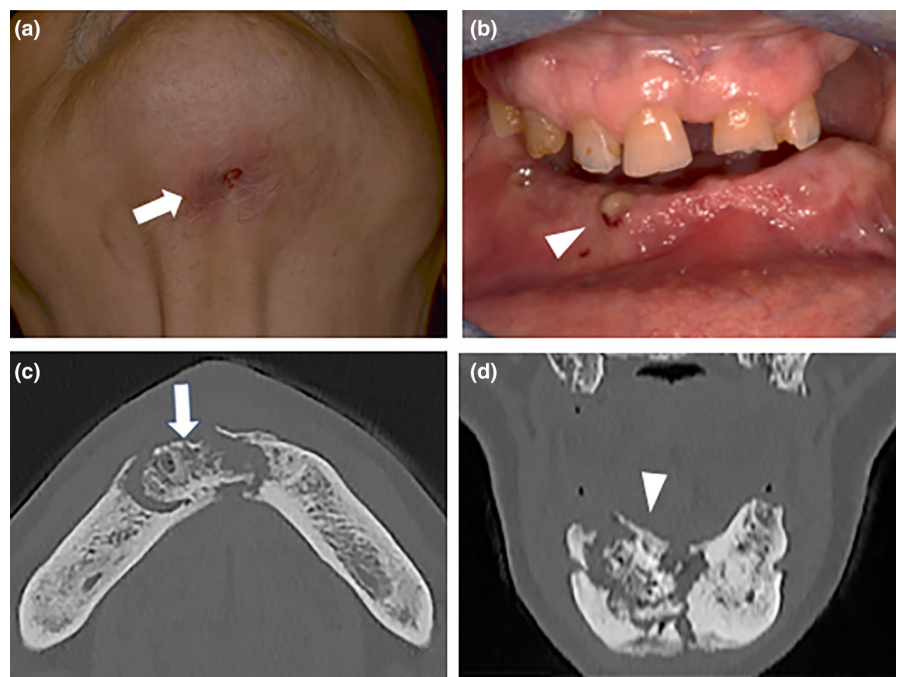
Stage 3, Complicated MRONJ. Panel a: clinical view showing a submental cutaneous fistula (white arrow). Panel b: intra-oral view showing single mucosal sinus track with purulent discharge at the level of the inferior gingiva (white arrow). Panel c and d: CT axial and coronal reconstructions display diffuse bone sclerosis encompassing the basal bone, sequester formation and pathologic mandibular fracture (white arrow and white arrow-head respectively).
